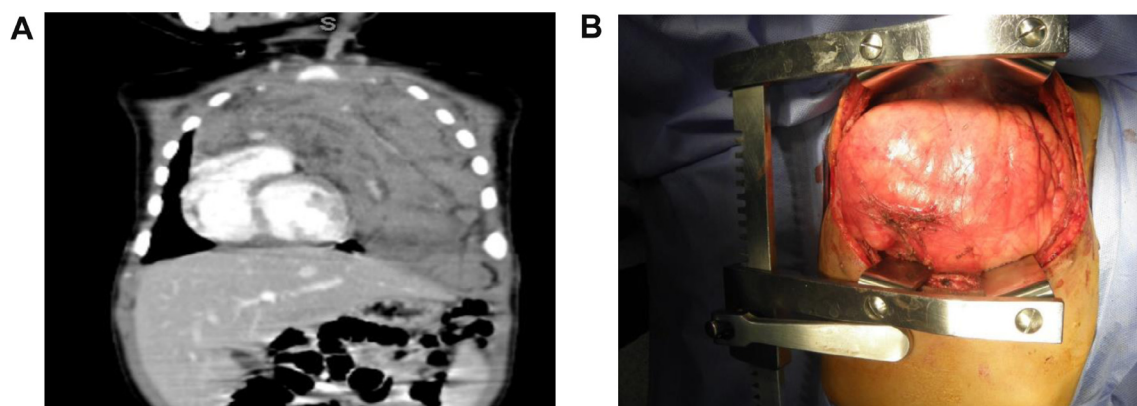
(A) CT coronal view of mediastinal thymolipoma. (B) Intraoperative view of clamshell approach.
